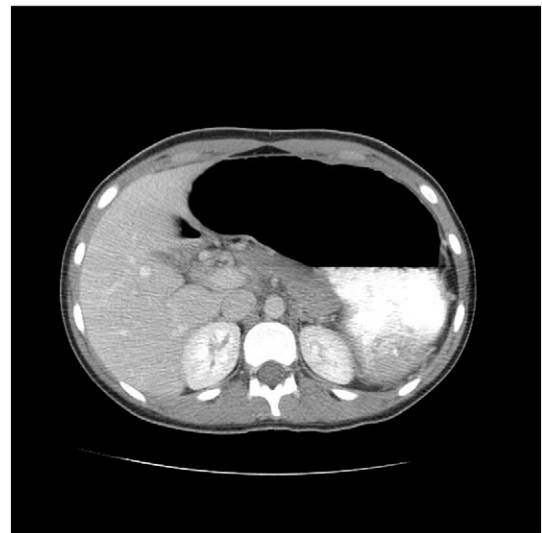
Case 1. Pre-operative CT abdomen with intravenous and enteric contrast. Non-thrombosed spleen with torsed splenic hilar vessels.
